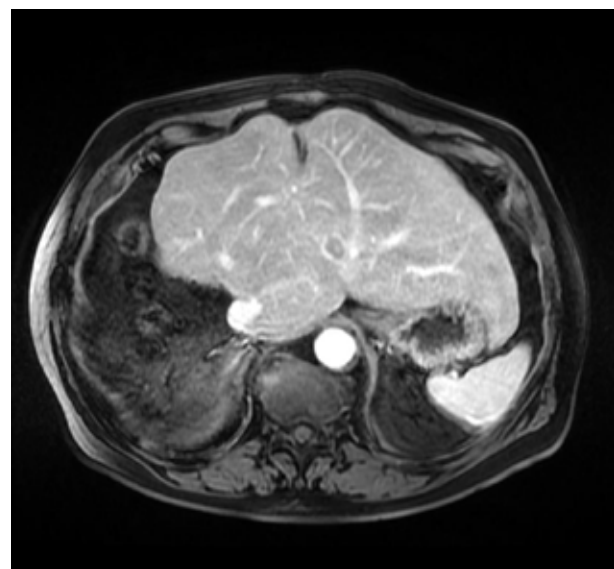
Pre-op MRI imaging.
